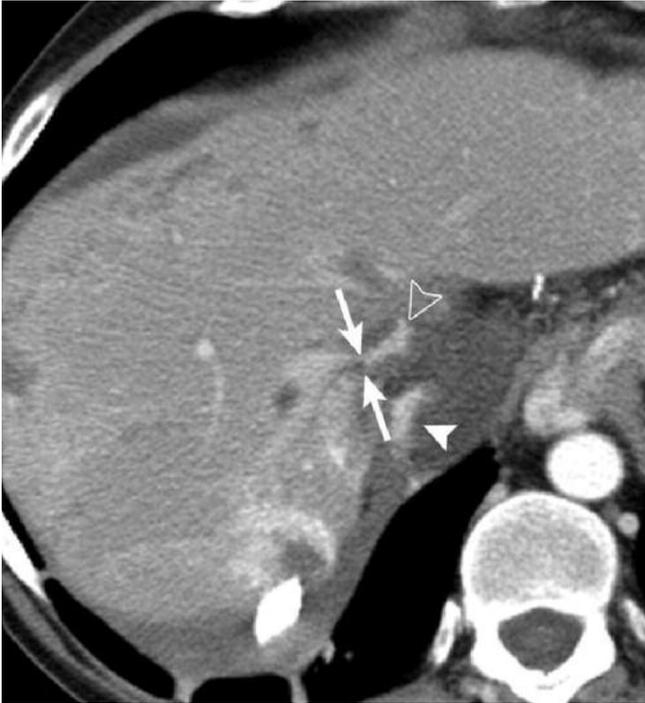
Contrast enhanced CT scan of the liver demonstrating a focal stenosis of the portal vein.
